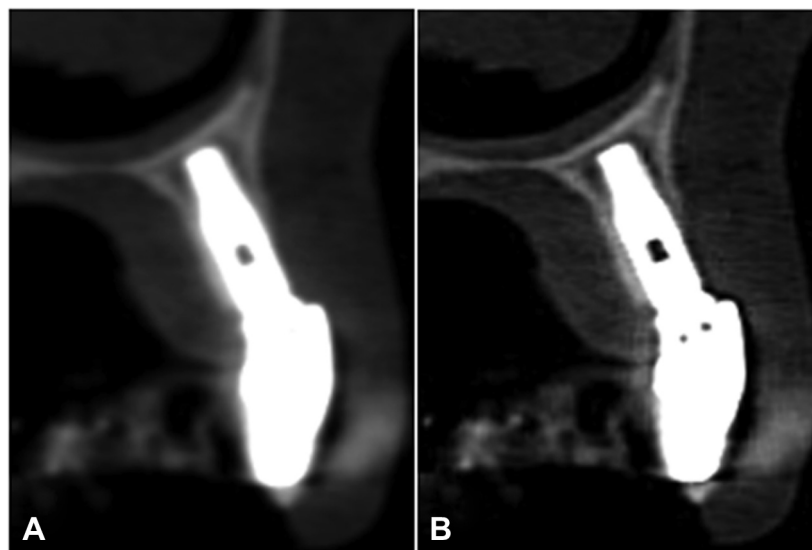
Sagittal CBCT slice of images acquired from a patient demonstrating the usefulness of the sharpen 3 × 3 filter (B), which enhanced the visualization of the cortical bone, implant surface and a periimplant dehiscence defect. The same slice in its original form is also presented (A).
